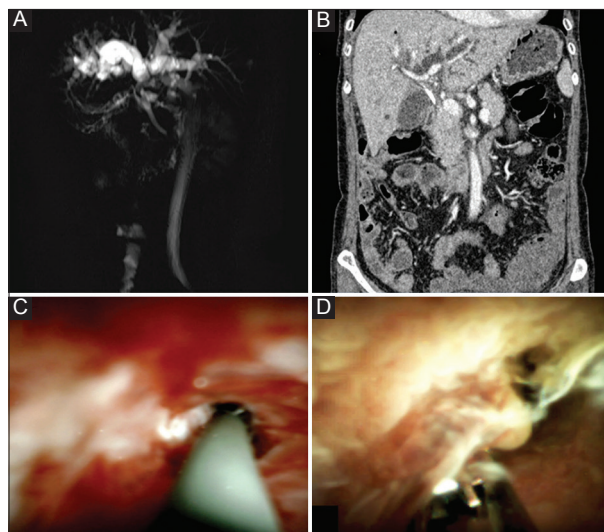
Diagnostic workup for malignant hilar obstruction: (A) reconstruction image of magnetic resonance cholangiopancreatography depicting type II hilar obstruction; (B) coronal reconstruction computed tomography image showing hilar obstruction; (C) Cholangioscopy image showing malignant stricture; (D) cholangioscopy-guided biopsy from papillary projections of cholangiocarcinoma (Image courtesy: Dr Saurabh Mukewar, Midas Hospital, Nagpur, India)
